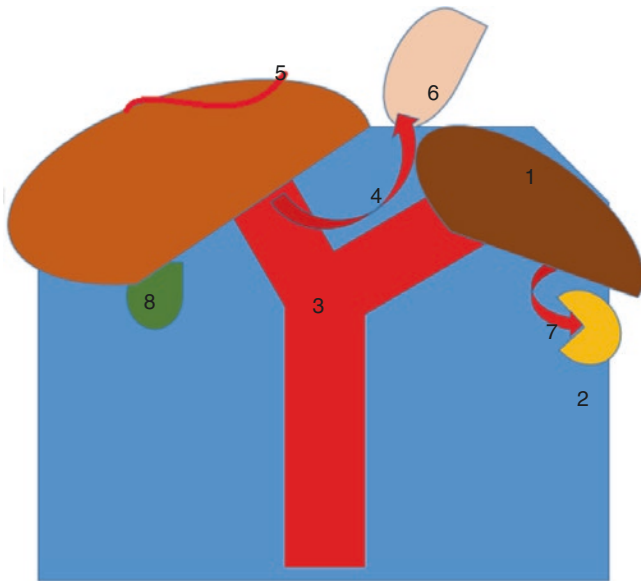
Ultrasonography signs of portal hypertension: (1) Splenomegaly; (2) Ascites; (3) Distension of the portal vein and drainage veins (splenic, superior mesenteric); (4) Porto-systemic collaterals; (5) Patent umbilical vein; (6) Thickening of the gastric wall; (7) Spontaneous spleno-renal shunt; (8) Thickening of the gallbladder wall
